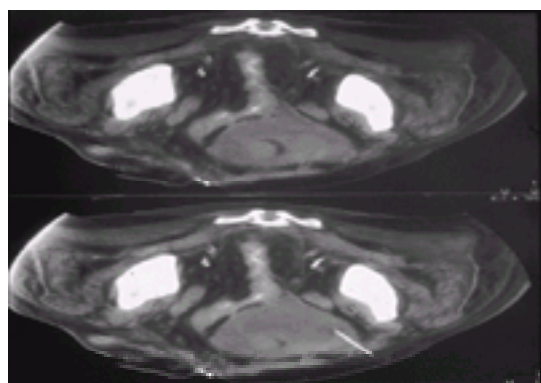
Abdominal CT showing a perigraft collection of pus in a patient with an infected aortic graft.
